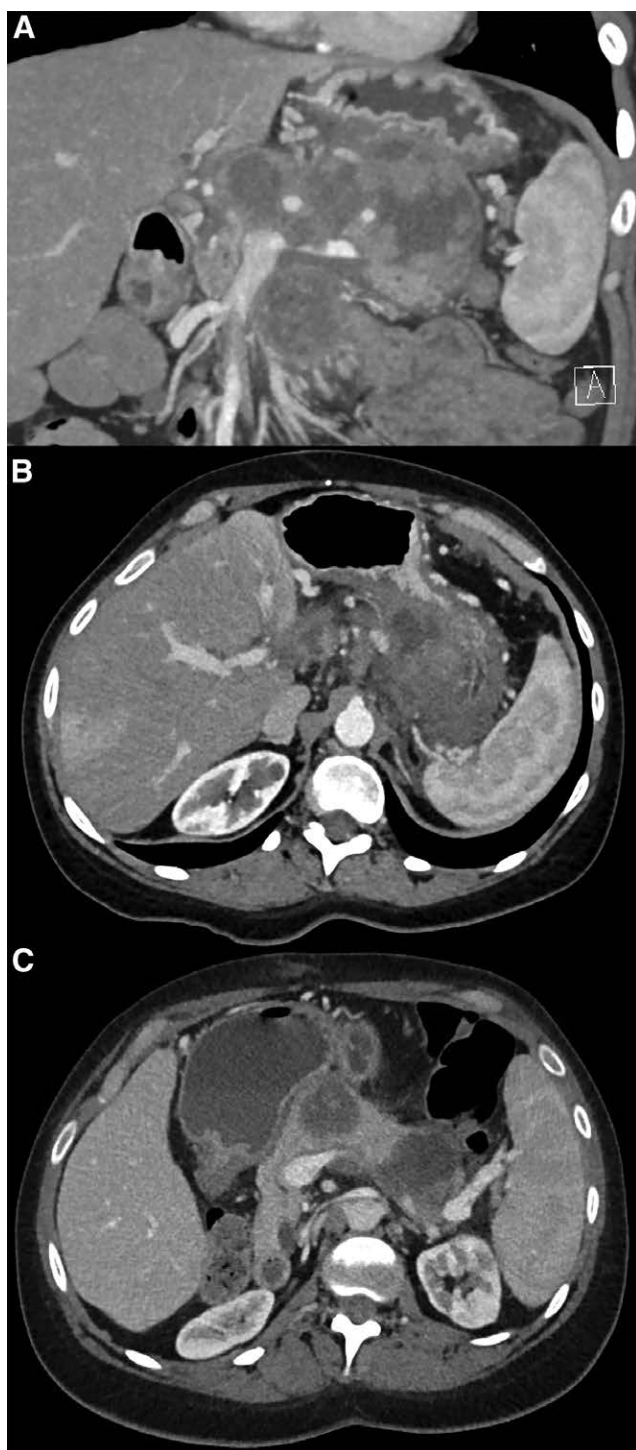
Triple-phase computed tomography imaging of the pancreas at time of admission. A, Multiple complex cystic and solid masses within and adjacent to the pancreas. Note vascular involvement with encasement and occlusion of the splenic vein. B, Mass extending cranially from pancreatic tail into the lesser sac measures 6.3×6.1 cm. C, Mixed enhancing and hypoenhancing cystic lesion. The claw sign suggests origin from within the pancreas. Of note, the pancreatic parenchyma appears preserved.
